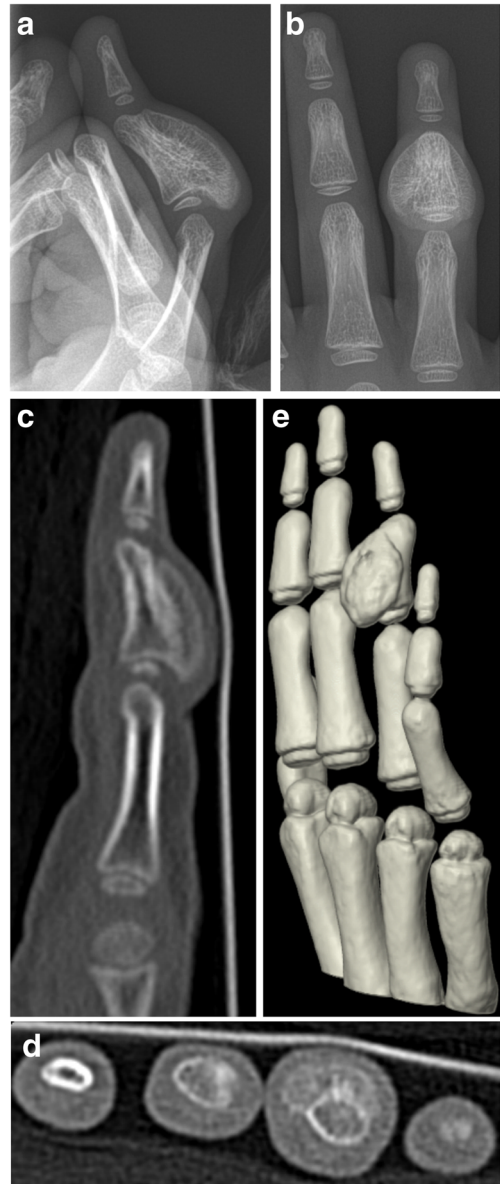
a, b Radiographs and c–e CT reconstructions at 3-month follow-up
